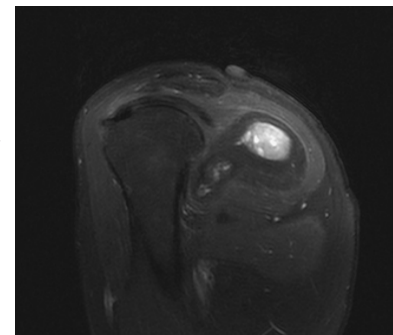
T2-weighted magnetic resonance imaging of the sagittal plane revealed mild signal enhancement with poorly defined margins within the cyst, which suggested chondroosseous calcification or mineralization within the adipose tissue.
